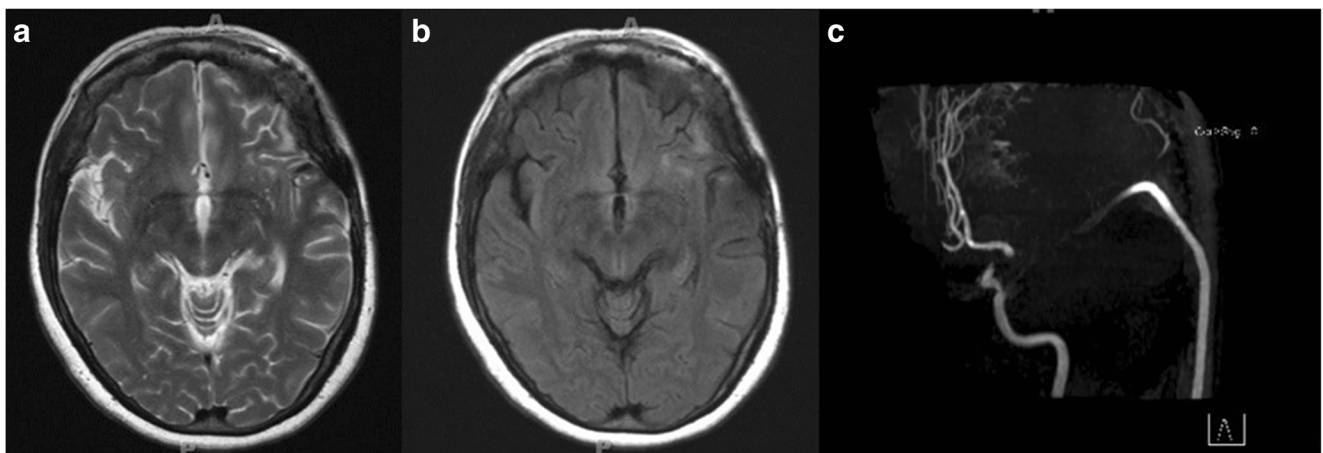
a Three-month follow-up T2 MRI showing complete resection of gauzoma. b Three-month follow-up FLAIR MRI showing complete resection of gauzoma. c Three-month follow-up MRA demonstrating patency of MCA bypass
